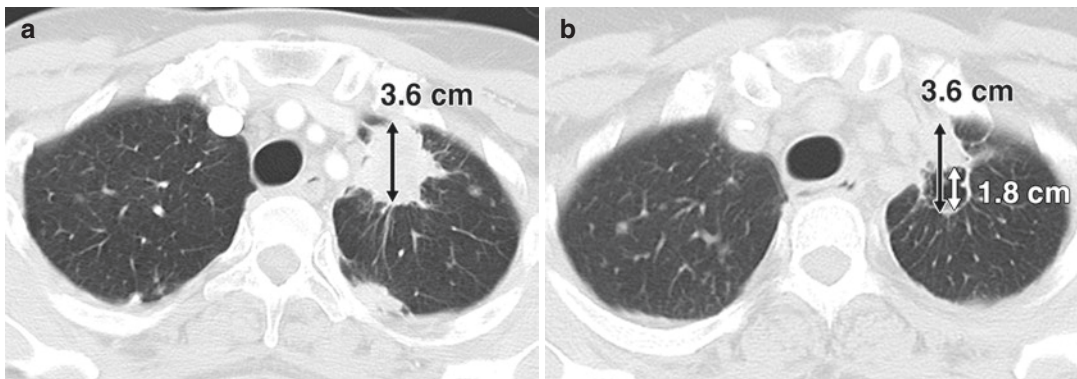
A 53-year-old woman with stage IV adenocarcinoma of lung treated with paclitaxel, carboplatin, and concurrent vascular epidermal growth factor receptor inhibitor, bevacizumab. (Reprinted with permission from AJR Am J Roentgenol. 2012;198: 737–745). (a) Baseline CT scan of chest before bevacizumab therapy shows spiculated mass (double-ended arrow) in left upper lobe, which measured 3.6 cm in longest diameter. (b) Follow-up CT after 6 weeks of therapy reveals development of tumor cavitation. Measurement of lesion by Response Evaluation
